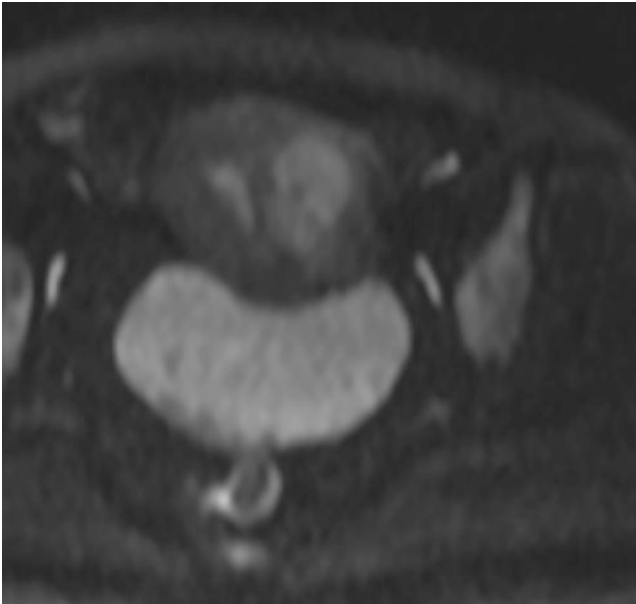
Leiomyosarcoma of uterus. On DWI, the mass showed restricted diffusion signal
